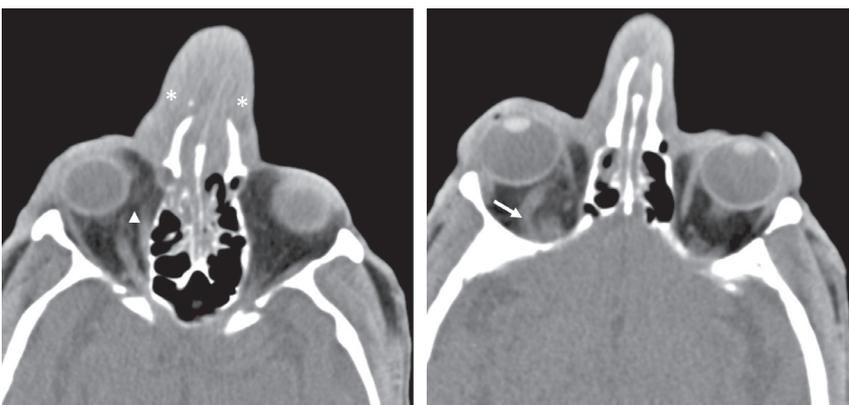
Axial non contrast CT of the face (A) caudal to (B). A, Diffuse thickening of the nasal and soft tissues (asterisks). There is stranding of the post-septal fat planes (arrow head) consistent with post septal cellulitis. B, Enlargement of the superior ophthalmic vein (arrow) raising the possibility of cavernous sinus thrombosis.
